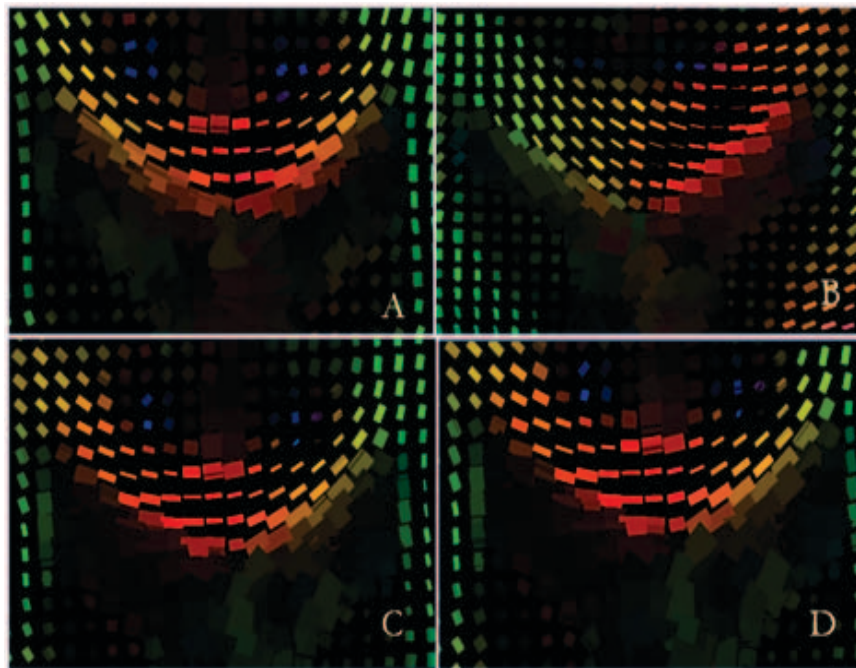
Axial tensor glyph maps of the genu of corpus callosum. (A) Original tensor from DWI dataset. (B) Without any reorientation applied. (C) Results from gradient rotation method and (D) tensor reorientation.
